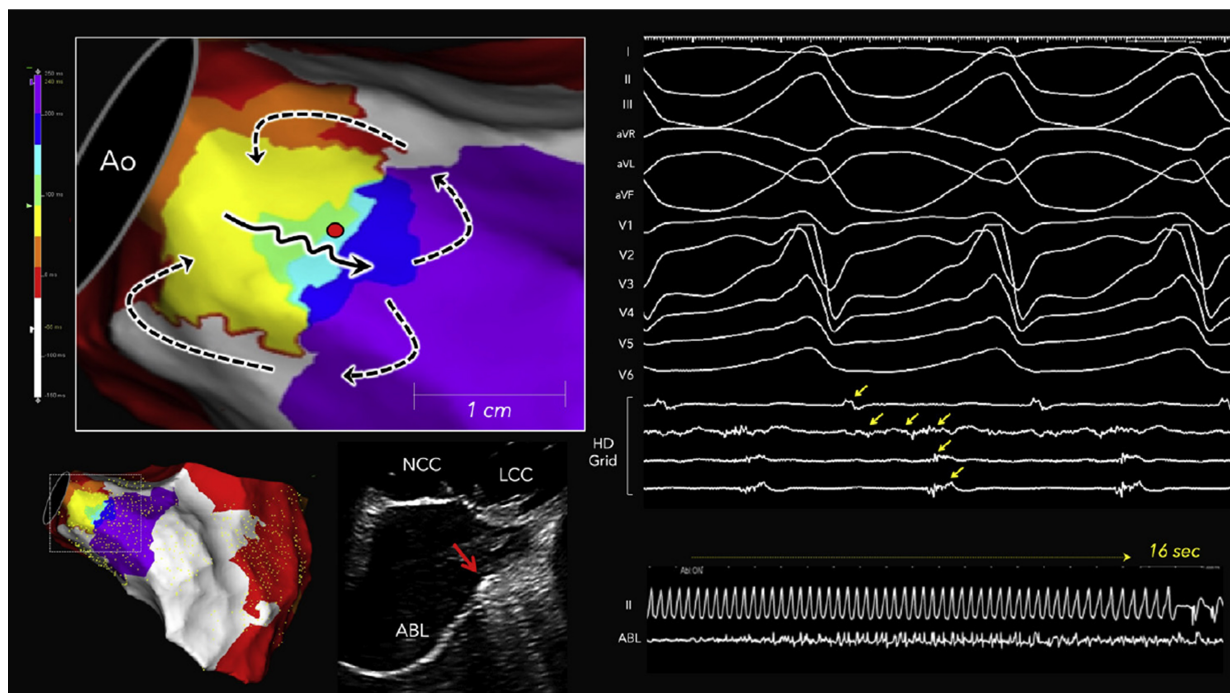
Localized reentry circuit within the periaortic septum in a nonischemic cardiomyopathy patient. The yellow arrows indicate diastolic potentials. Long fractionated potentials spanning the entire diastolic phase were recorded by a single bipolar electrode located in the periaortic septum during VT. The black solid and black dashed arrows indicate the isthmus and outer loop activation in the reentrant circuit, respectively. The red dot indicates the site where radiofrequency ablation successfully terminated the tachycardia, and the intracardiac echocardiographic image shows the ablation catheter positioned at the periaortic septum (red arrow). This figure is reproduced from the original manuscript with permission from Elsevier [38]. ABL, ablation catheter; Ao, aorta; ICE, intracardiac echocardiography; LCC, left coronary cusp; NCC, noncoronary cusp.
